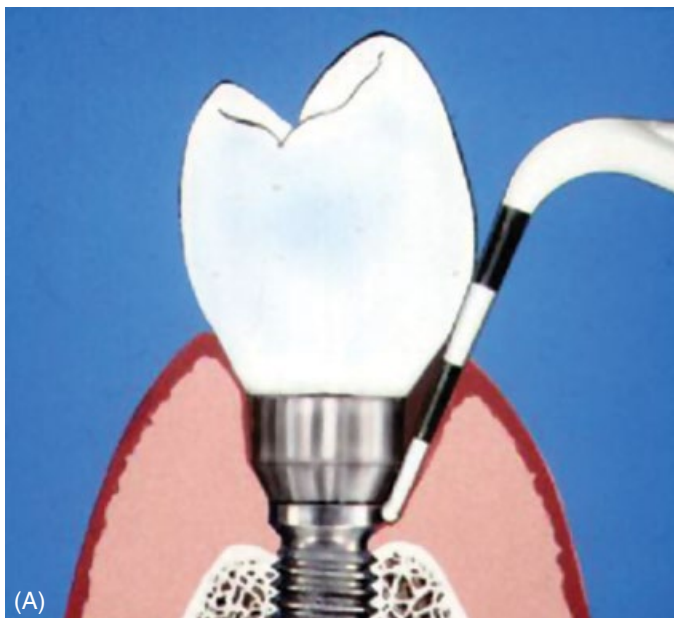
(A) Proper positioning to show probing around restored implant. (B) A plastic periodontal probe (see Figure 47.11B) can be gently swept through the peri-implant sulcus to visualize symptoms of inflammation or disease. The depth of the sulcus is surgically created and therefore corresponds to abutment collar height, rather than an indication of attachment loss. A better indicator of bone loss is a radiograph.
